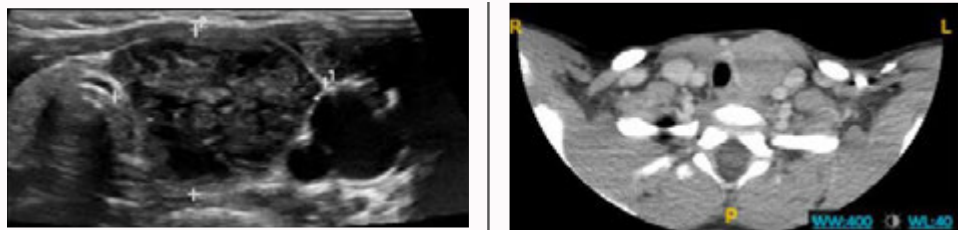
A) US thyroid showed large heterogeneous irregular left thyroid lobe nodule. B) CT neck showed ill-defined heterogeneous lesion occupying the left thyroid lobe measures approximately 2.5 cm x 2.5 cm x 3 cm causing mild compression and displacement on the trachea.
